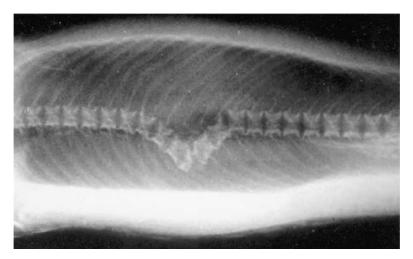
Dorsal-view X-ray of a rainbow trout (*Oncorhynchus mykiss*) revealing severe spinal misalignment and fractured vertebrae caused by electrofishing. (Photograph provided by and used with permission of N. G. Sharber, Flagstaff, Arizona; reproduced from Snyder (2003), Figure 16-top.)
